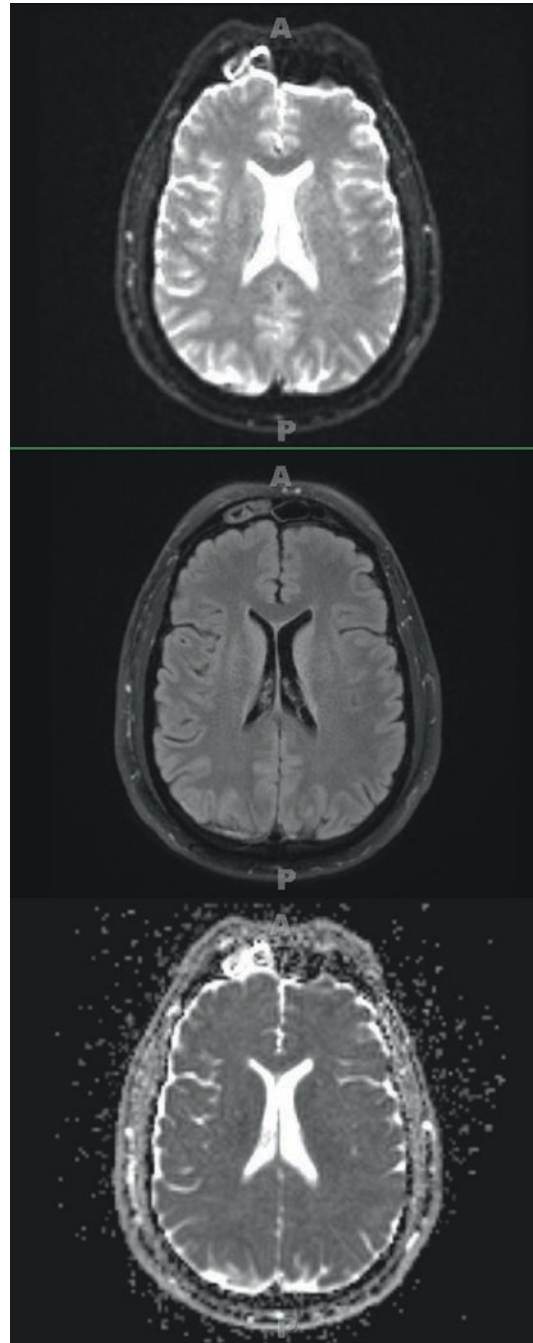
A representative image from the MRI of the brain is shown
